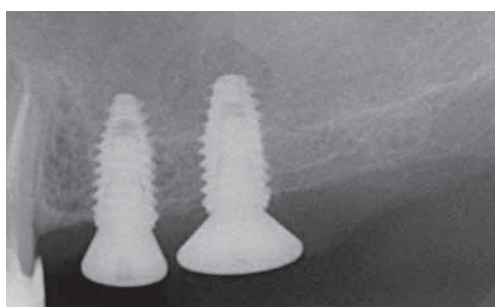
X-Ray after implant placement: note a small 6 mm diameter access window and lack of biomaterial.
